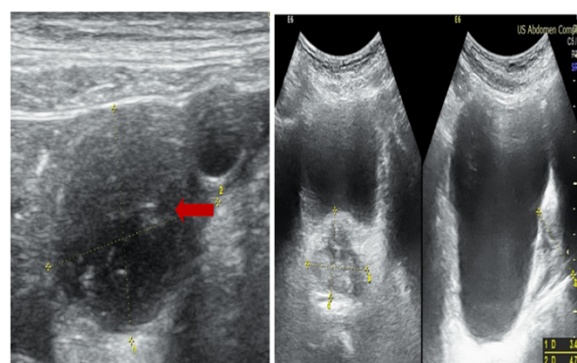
Abdominal Ultrasound shows mucocele appendix in right iliac fossa.
